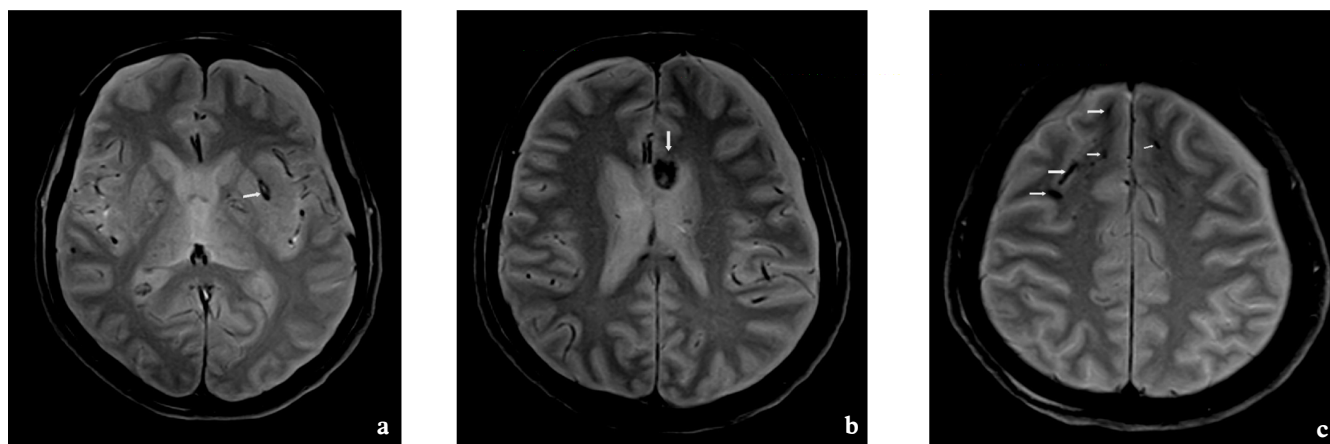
Axial MRI T2* images, 20 days after DOI. Better detection of multiple hemorrhagic shearing foci consistent with DAI, seen as hypointense lesions (blood products/hemosiderin) in left subinsular region (a), in anterior part of corpus callosum (b) and in the frontal lobes (c) – arrows.
